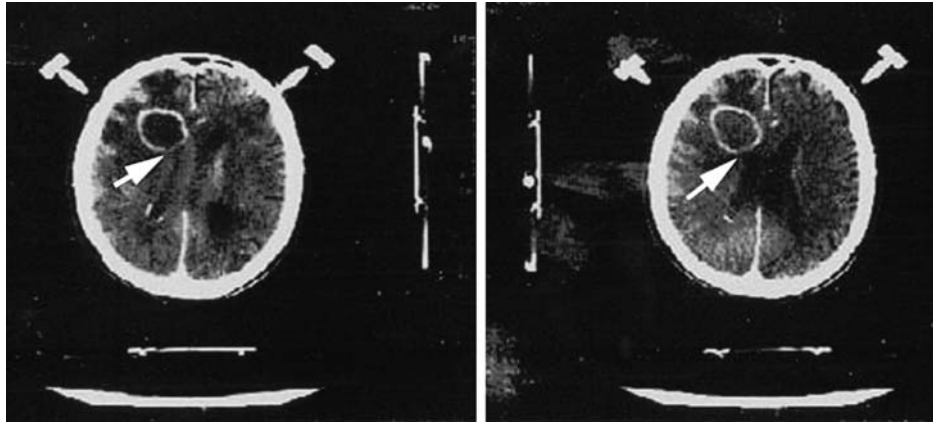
Coronal slices from post-contrast brain CT showing a minimally contrast-enhancing right frontal round mass (diameter, 4 cm), adjacent to the anterior horn of the lateral ventricle (arrow). The lesion was surrounded by a hypodense halo consistent with oedema and produced a shift of the brain midline to the left.
